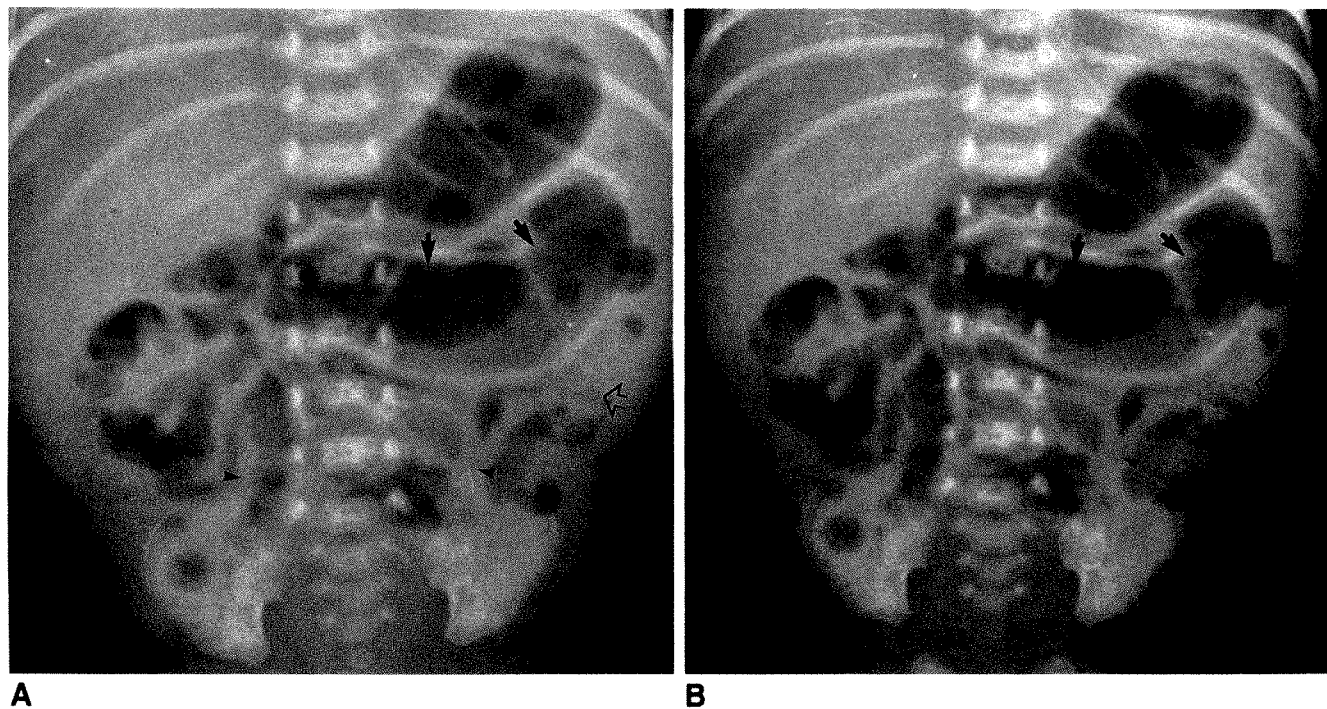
Conventional (A) and digitally manipulated (B) radiographs of abdomen in a neonate with necrotizing enterocolitis (NEC). Window width and level have been adjusted for digital image to optimize definition of intraabdominal structures, resulting in greater contrast. A dilated segment of bowel (solid arrows) and several areas of increased soft-tissue separation between intraluminal bowel gas (arrowheads), compatible with bowel-wall edema and/or intraperitoneal fluid, are signs suggestive of NEC. Left flank region contains an area of mottled lucency (open arrow) that could be either cystic pneumatosis or feces mixed with air.
